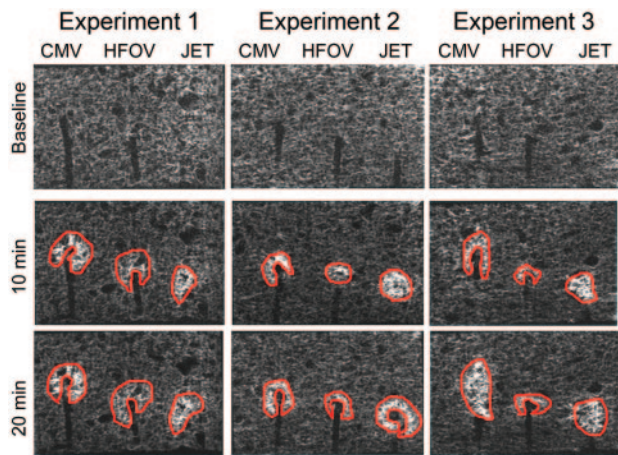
This figure shows MR images obtained at baseline and at 10 and 20 min after cumulative aerosol administration in 3 series of experiments. Each image represents a single slice; to ensure that the same slices were sampled at the 3 time points, the sponge was placed in the scanner in exactly the same position at the 3 time points. In each experiment, aerosols from conventional mechanical ventilation, HFOV and HFJV were administered simultaneously in a single sponge, which served as a lung model. The top panel represents images obtained at baseline. Gadopentetate dimeglumine (Gd-DTPA) is visualized in post-aerosol images at both 10 and 20 min with all ventilators and in all experiments.
